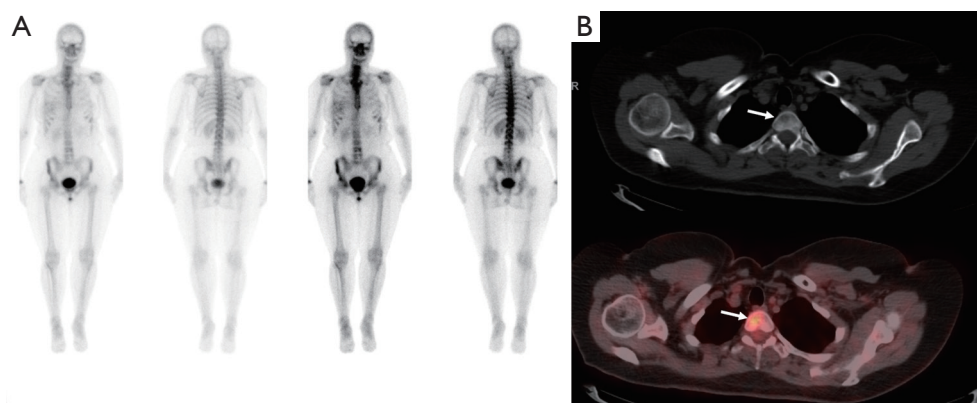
Supplemental case of a 54-year-old female with newly diagnosed right inflammatory breast cancer. (A) Bone scan performed at the time of diagnosis demonstrates focus of increased activity in the right 8th rib and increased uptake in the right sacroiliac joint/iliac crest with no uptake in the spine. The patient subsequently underwent CT chest and abdomen with contrast (not pictured) demonstrating no evidence of osseous metastasis. (B) FDG PET-CT demonstrates focal lytic T2 vertebral body abnormality with increased FDG uptake (arrows) suspicious for metastasis which was confirmed on subsequent MRI thoracic spine with contrast.
